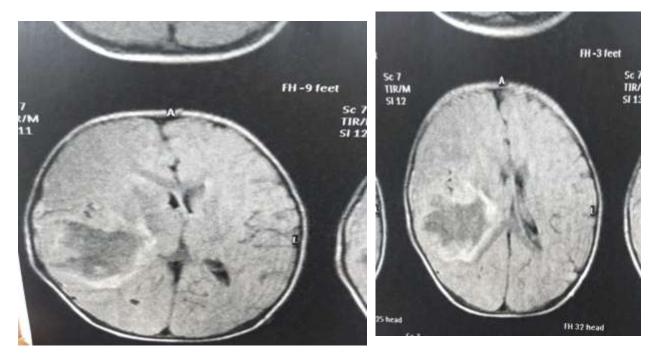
MRI Showing Hge inside tempro parietal tumor
